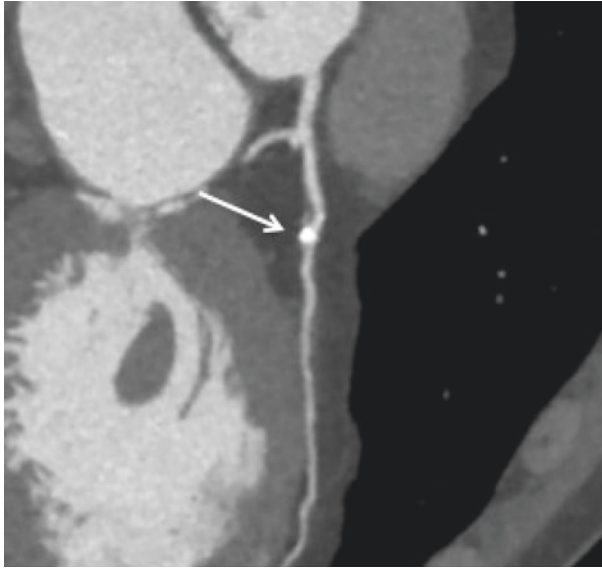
CT Coronary Angiogram in a 63-year patient with atypical symptoms. This shows a mixed calcified/non-calcified plaque, with significant positive remodeling and fissuring of the soft plaque with associated contrast penetration, labelled by the white arrow. This is a high risk plaque and the patient was referred for percutaneous coronary intervention
